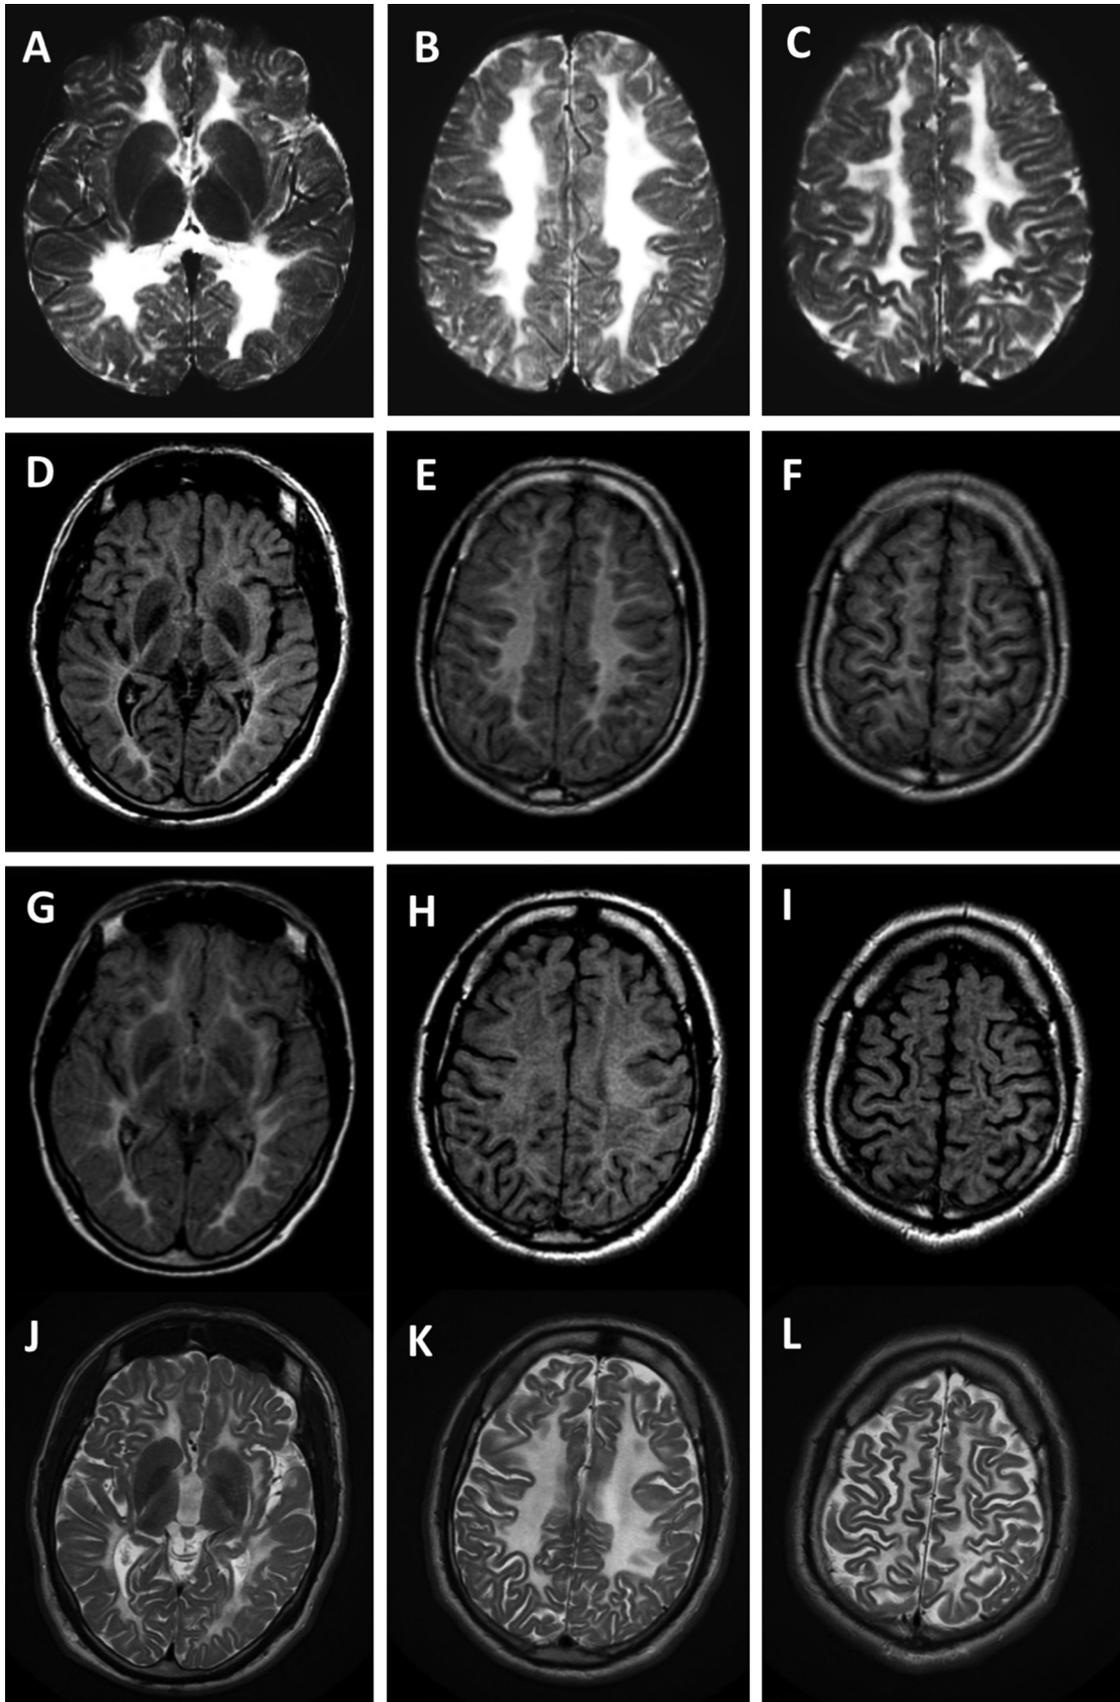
Brain magnetic resonance imaging of the proband at age three years (A–C), 19 years (D–F), and 26 years (G–L). Axial T2 images (A–C and J–L) and axial fluid-attenuated inversion recovery images (D–I) showed diffuse hypersignal of the cerebral white matter with diffuse cerebral atrophy but without progression or cystic changes.
